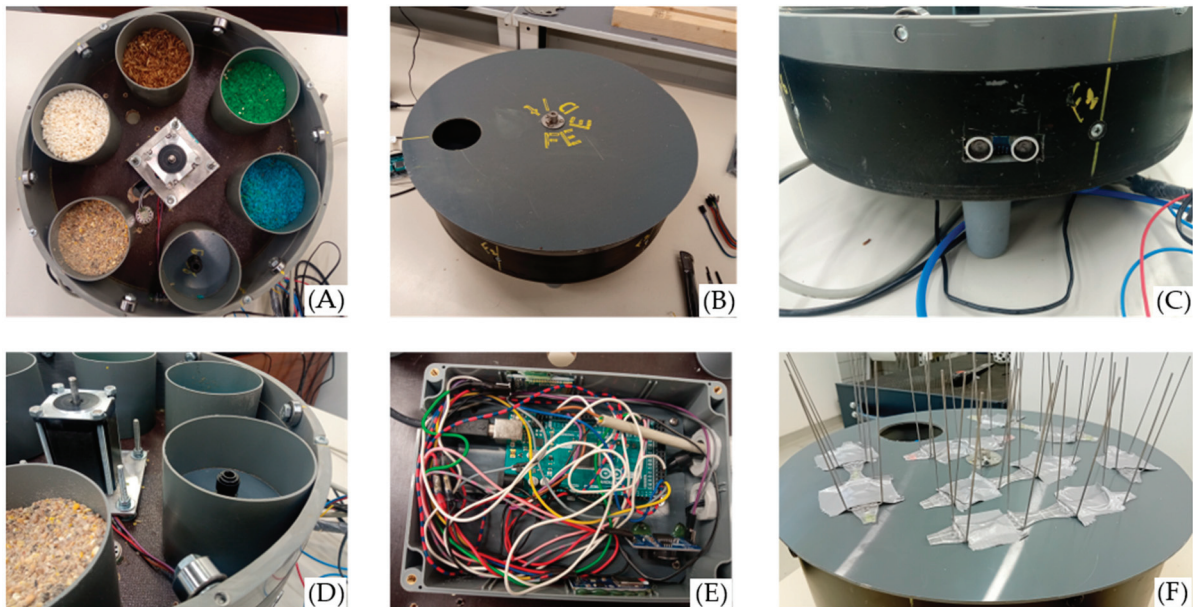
The proposed interactive feeder. (A) The food containers, (B) the rotating disc, (C) the ultrasonic sensor on the side of the device, (D) metallic wheels aiding the rotation, (E) the box containing the electronics, positioned on the bottom, and (F) the final form of the feeder with pigeon spikes taped on the disc.
